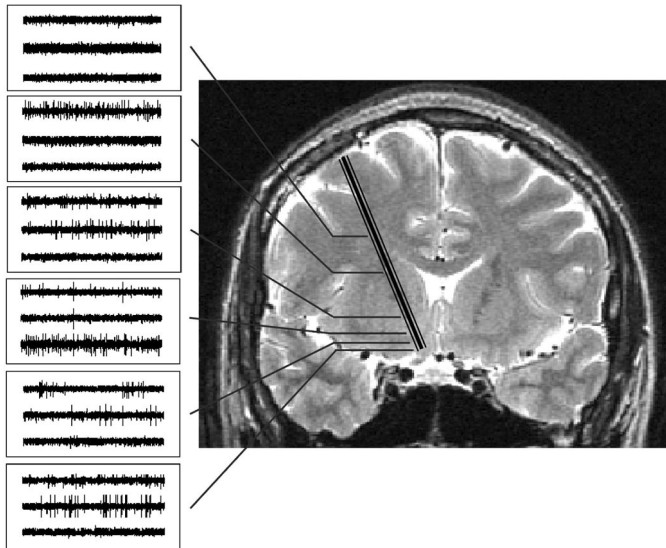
Reconstructed electrode trajectory superimposed on preoperative coronal MRI scan. Activity in the medial and lateral electrodes corresponds to the caudate and putamen, respectively. Tracings on the top of each inset correspond to neuronal activity recorded from the medial electrode, whereas tracings on the bottom of each inset correspond to activity recorded from the lateral electrode.
